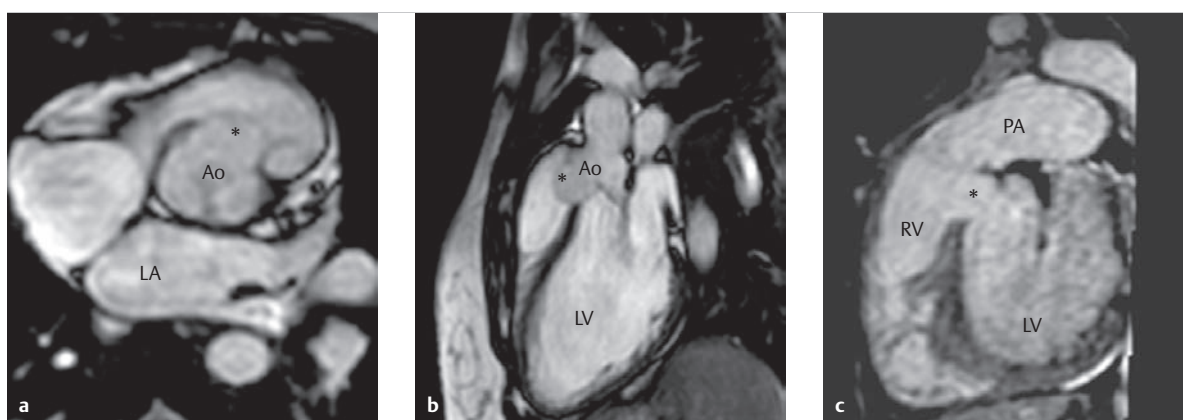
Subpulmonary or infundibular VSD (type B) with prolapsed right coronary cusp. The SSFP cine MRI sequence and LVOT slice clearly show the right coronary cusp prolapsed into the RVOT (a, b, asterisks). The short-axis slice depicts the subpulmonary VSD (c, asterisk).
